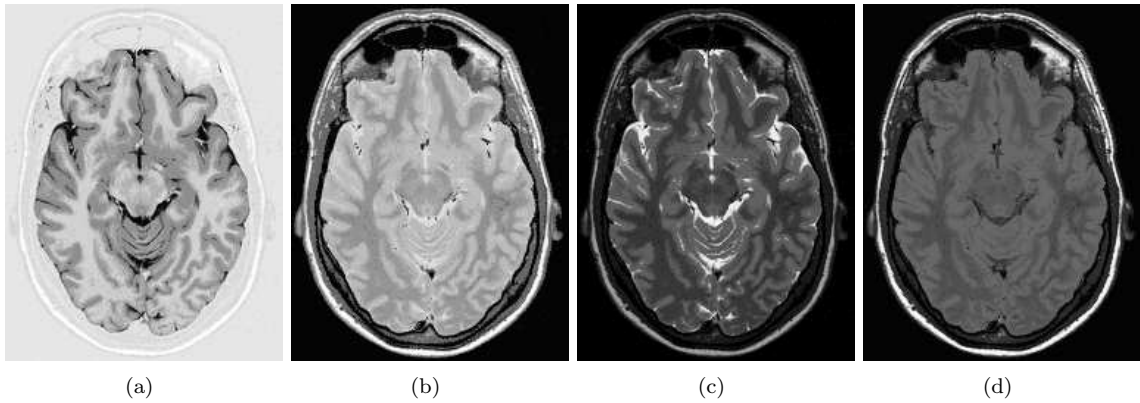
Reconstructed MR data: IRTSE(a), VE (PD) (b) VE (T2) (c) and FLAIR (d)
